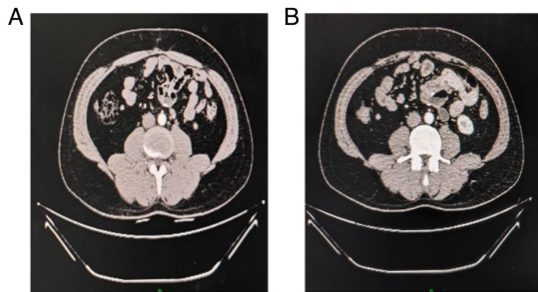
Enhanced computed tomography showed no tumor recurrence in the surgical area and no distant metastasis in other organs. (A) 1-year follow-up after surgery. (B) 5-year follow-up after surgery.
